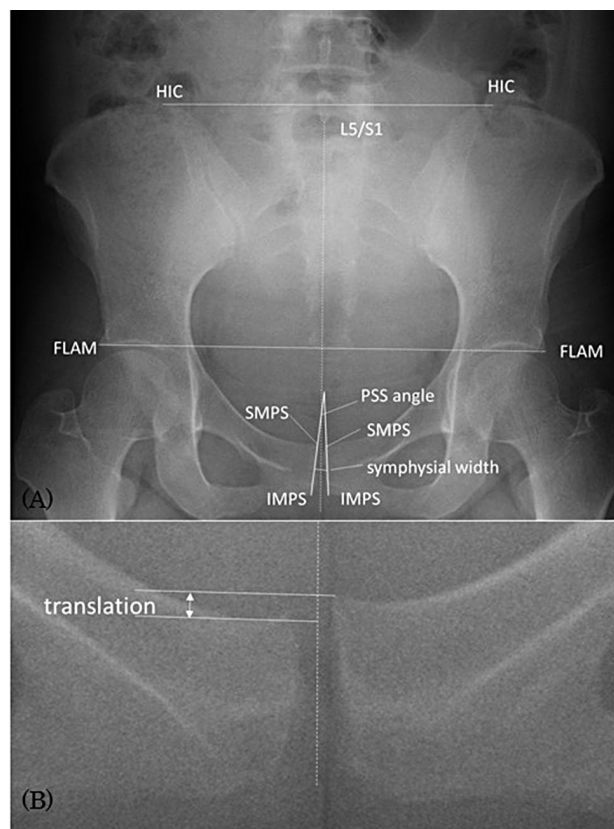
Radiographic measurements. The highest point of iliac crest (HIC), the furthest lateral points of acetabular margin (FLAM), superior margin of the pubic symphysis (SMPS), and the inferior margin of the pubic symphysis (IMPS) are marked on each radiograph as shown (A). The pubic symphyseal surface (PSS) angle is defined as the angle between two lines combined SMPS and IMPS on each side. The symphyseal width is the distance between midpoints of SMPS and IMPS on each side. The distance between two lines perpendicular to the reference line (L5-midpoint of IMPSs) through the SMPS on the right and left represent the translation of pubic arches (B).
